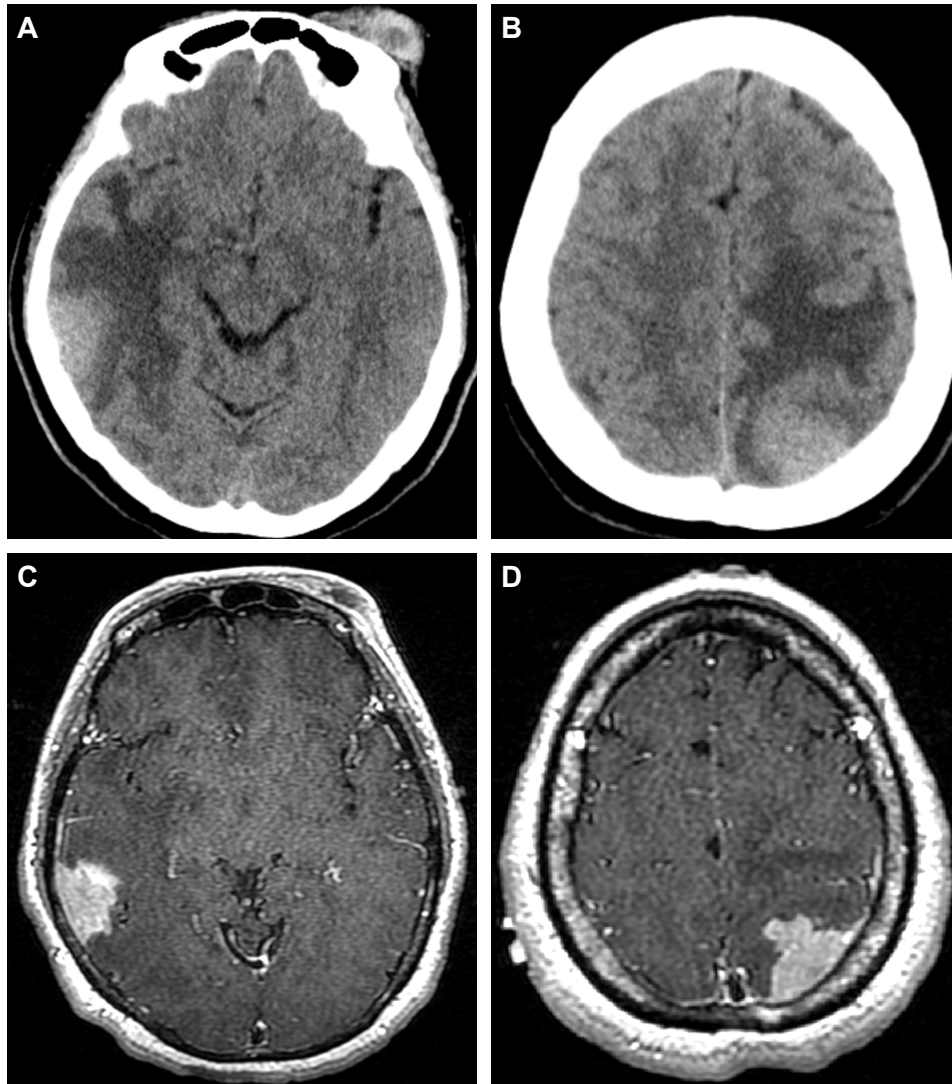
Computed tomography of the brain indicating two homogeneously hyperdense masses over the right temporal lobe (A) and the left parieto-occipital region with obvious white matter edema (B). T1-weighted contrast-enhanced magnetic resonance imaging of the brain showing dura-based masses over the right temporal (C) and the left parieto-occipital regions (D).
